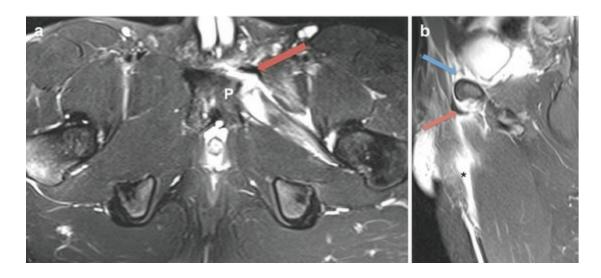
A 19-year-old male athlete with tenoperiosteal detachment of the rectus abdominis-adductor longus (RA-AL) aponeurosis. (a) Axial and (b) coronal short tau inversion recovery MRI show avulsion of the proximal tendon of the left adductor longus (AL) with tenoperiosteal detachment of the RA-AL aponeurosis (red arrow) from the pubic tubercle (P). The tear extends to the distal rectus abdominis attachment (blue arrow). Note fluid signals tracking along the torn AL muscle (asterisk), consistent with hemorrhage
